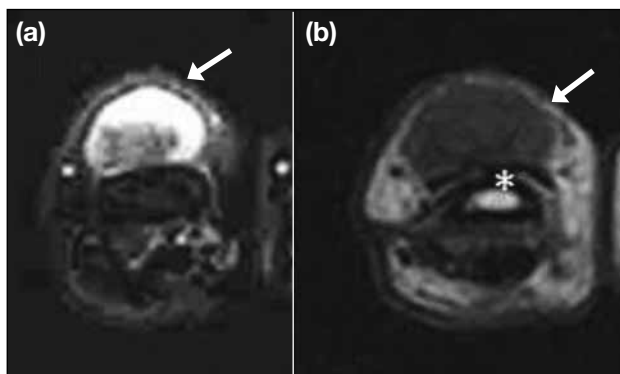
Magnetic resonance images in the same patient as Figure 18 and Figure 19. (a) T2-weighted fat-saturated axial magnetic resonance image of the left finger showing a lobulated lesion (arrow) over the dorsal aspect of the fifth proximal phalanx with heterogenous T2 signal intensity. (b) T1-weighted axial magnetic resonance image showing corresponding hypointense signal. Underlying hypointense cortical rim (asterisk) is intact.
